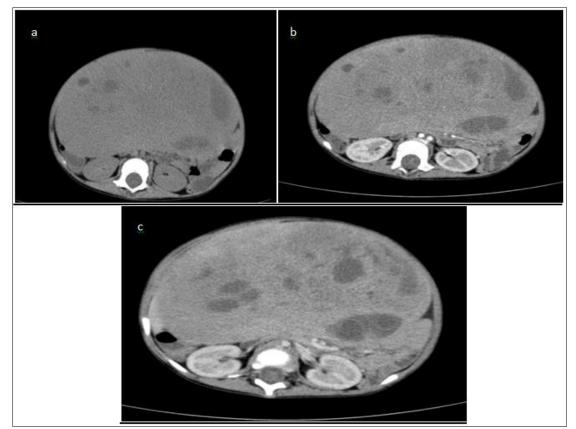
Abdominal CT scan without (a) and with PDC injection (b and c) shows the presence of a large hepatic mass at the expense of the left lobeHeterogeneous isodense, seat of hypodense zones, heterogeneously enhanced after injection of PDC
